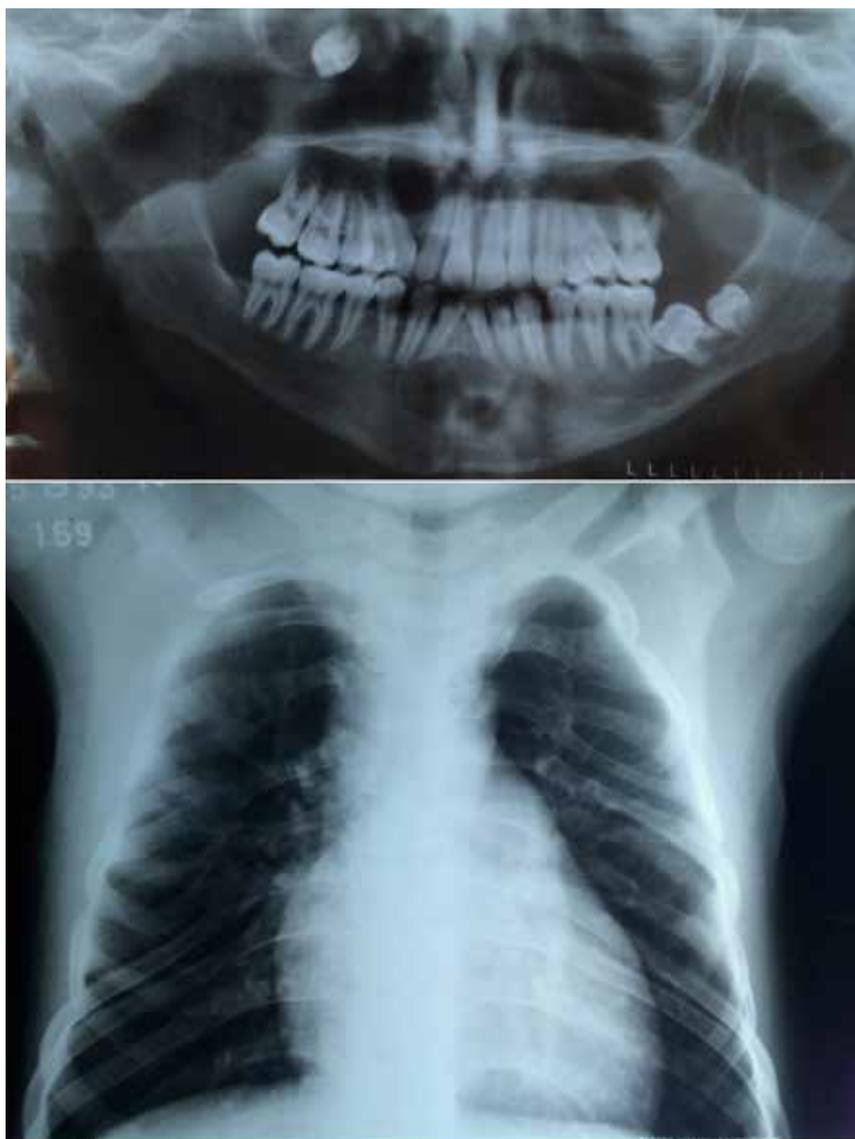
In the panoramic X-ray, well-delimited and unilocular radiolucent images can be seen in the maxillary region on the right and in the mandibular body, compatible with odontogenic keratocysts. In the radiograph of the thorax, multiple bifid ribs and scoliosis can be observed
